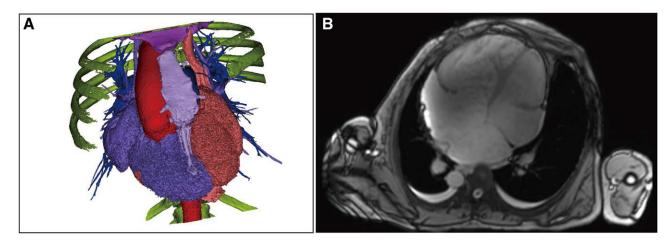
Preoperative imaging examination of the patient's heart. Three-dimensional cardiac reconstruction reveals the relative position of the heart within the thoracic cavity (A). Cardiac magnetic resonance imaging displays the sizes and positions of the heart's atrial and ventricular chambers (B).
